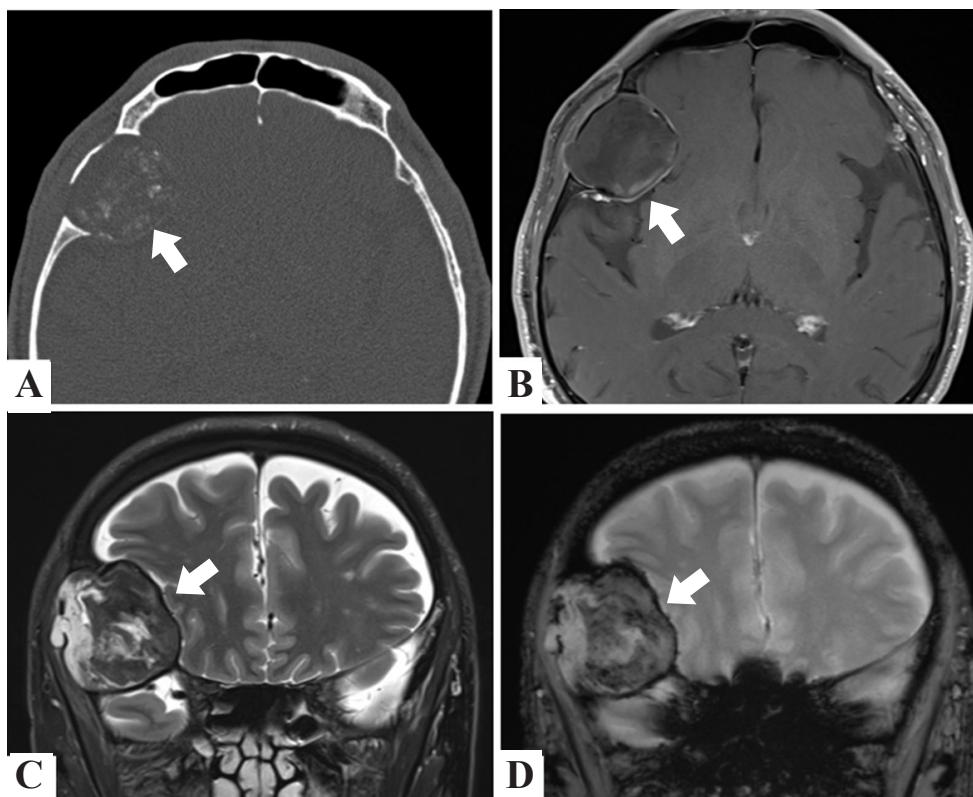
(A) CT scanning revealed a sharply demarcated bony defect(asterisk) and zones of calcification at the diploic space of the right sphenoid bone. (B) T1-weighted MRI with gadolinium demonstrated no contrast enhancement. (C) T2-weighted image showed mixed hypointense and hyperintense lesion. (D) Atypical internal hemorrhage on susceptibility image.
